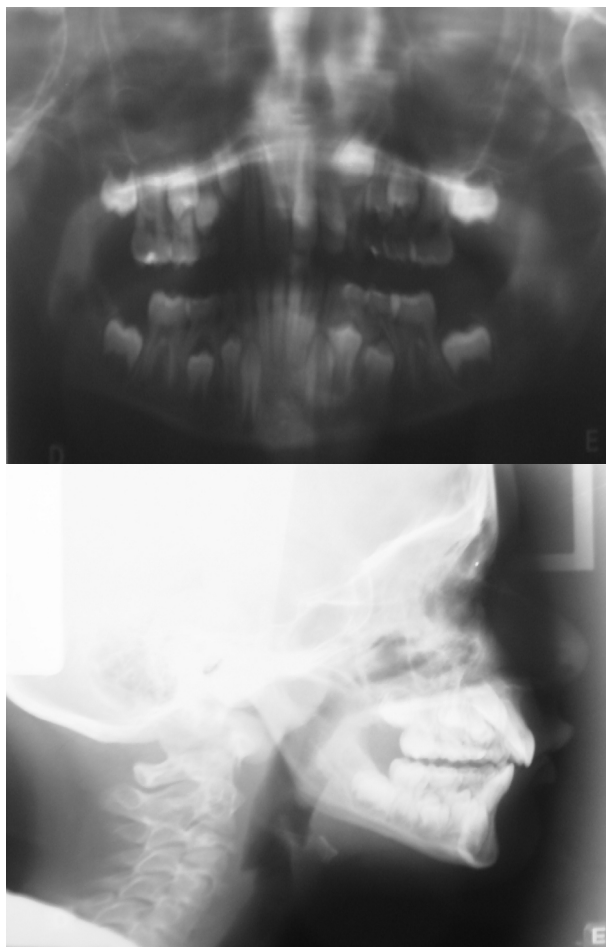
Radiography and panoramic x-rays of the face at the end of treatment.
